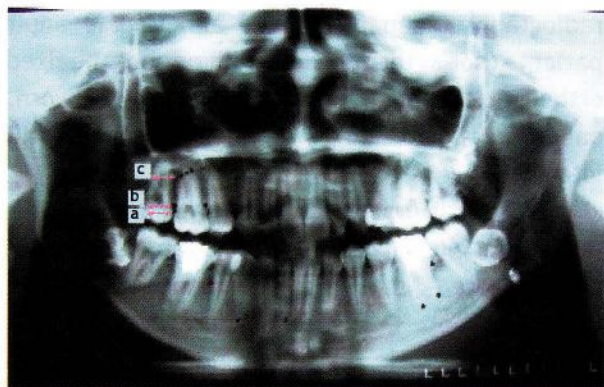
Radioanatomic points in panoramic radiograph.
